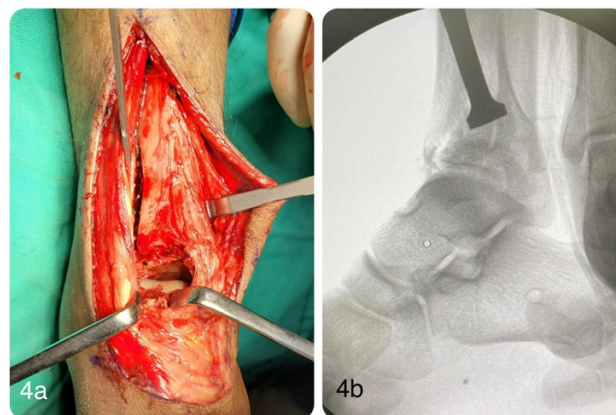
Figure 4a shows the impacted tibial plafond and the talar dome before disimpaction, and Figure 4b is the intraoperative radiograph showing the disimpaction of the tibial plafond done via the lateral column fracture site.
